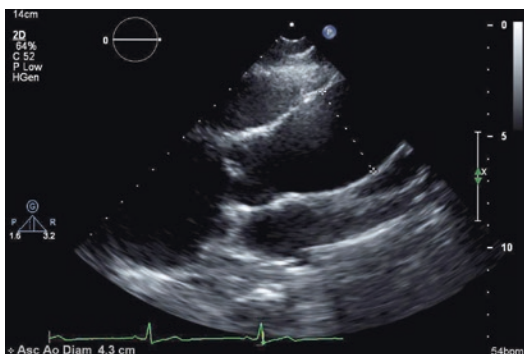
Transthoracic echocardiographic imaging of a patient with a unicuspid aortic valve showing a dilated ascending aorta
